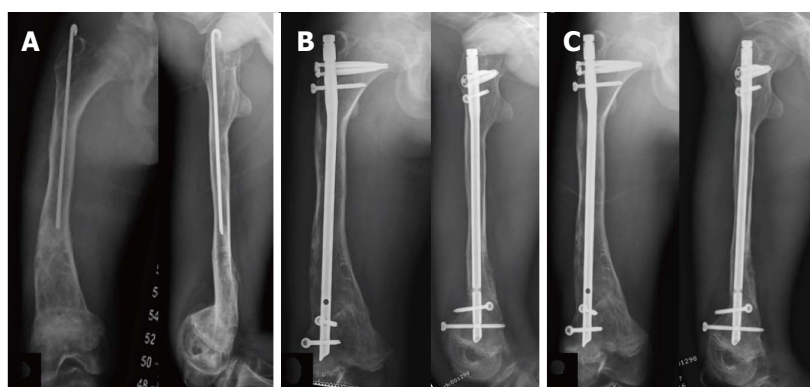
Clinical presentation of case 3 during the third operation. A 17-year-old male with type III osteogenesis imperfecta presented with progressive deformity after Rush pin fixation right shaft femur at early childhood. Plain radiographs in anteroposterior and lateral views on preoperative period (A), immediately after corrective osteotomy with humeral nail fixation (B), and 6 mo after humeral nail fixation (C).
